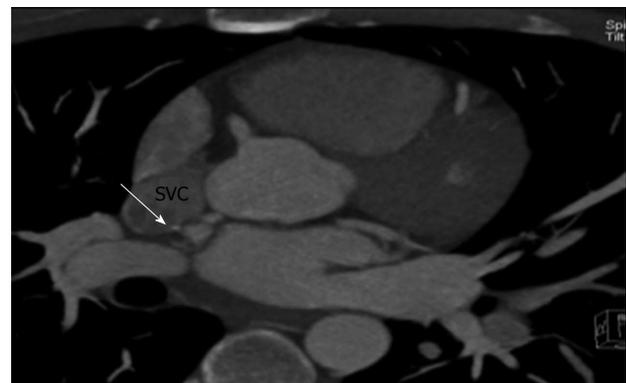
Right coronary artery to superior vena cava fistula. Axial maximum intensity projection reconstruction of coronary computed tomography angiography shows a fistula (arrow) between the right coronary artery and the superior vena cava (SVC).
